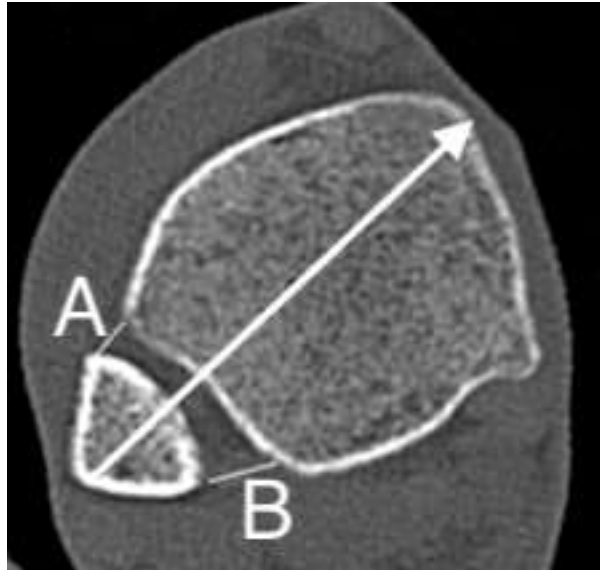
An axial CT image with an arrow indicating the trajectory of ideal screw placement, and with lines A indicating anterior space and B showing posterior space
